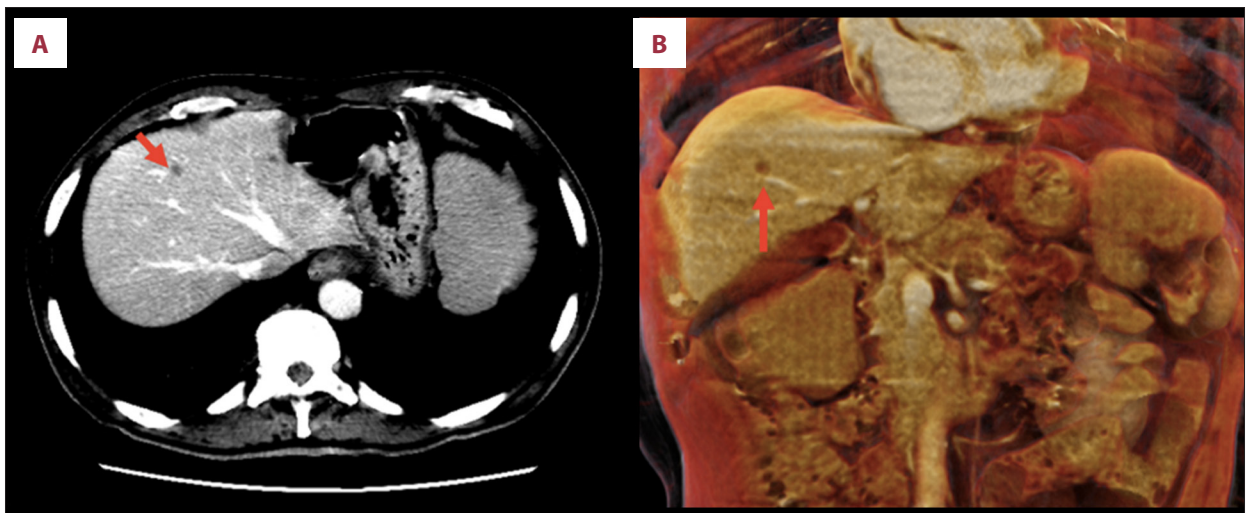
(A, B) Computed tomography scan showing a small, hypodense lesion in segment IVa of the liver (red arrow). Although the lesion was too small to be characterized, in the context of the colonic lesion, it was worrisome for metastasis.
